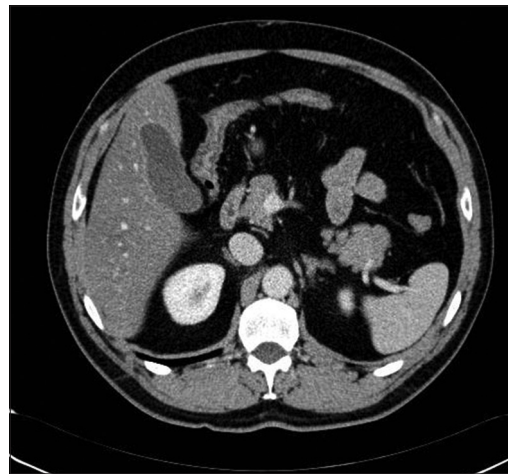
Abdominal CT: Gallbladder without gallstones
